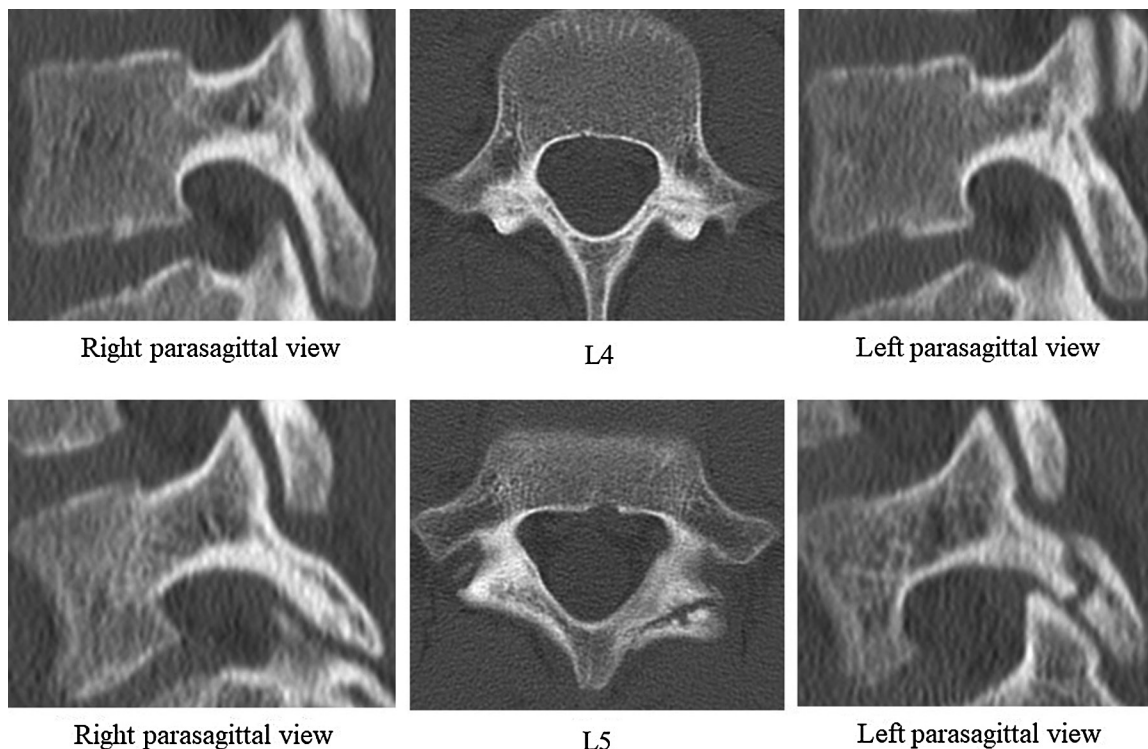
CT scans obtained 15 weeks later showing bone union at L4 and complete ossification of the bony defect in the lamina at L5 on the left. CT: computed tomography.
